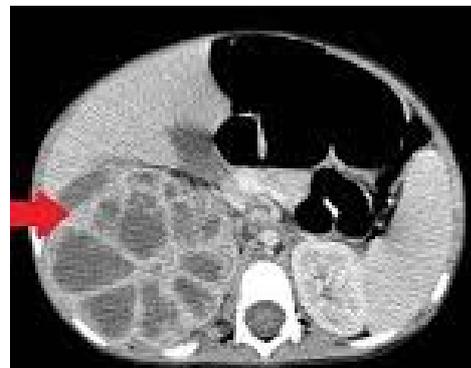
Selected image of the contrast enhanced CT of the abdomen. The typical Bear's paw sign is demonstrated (arrow).
